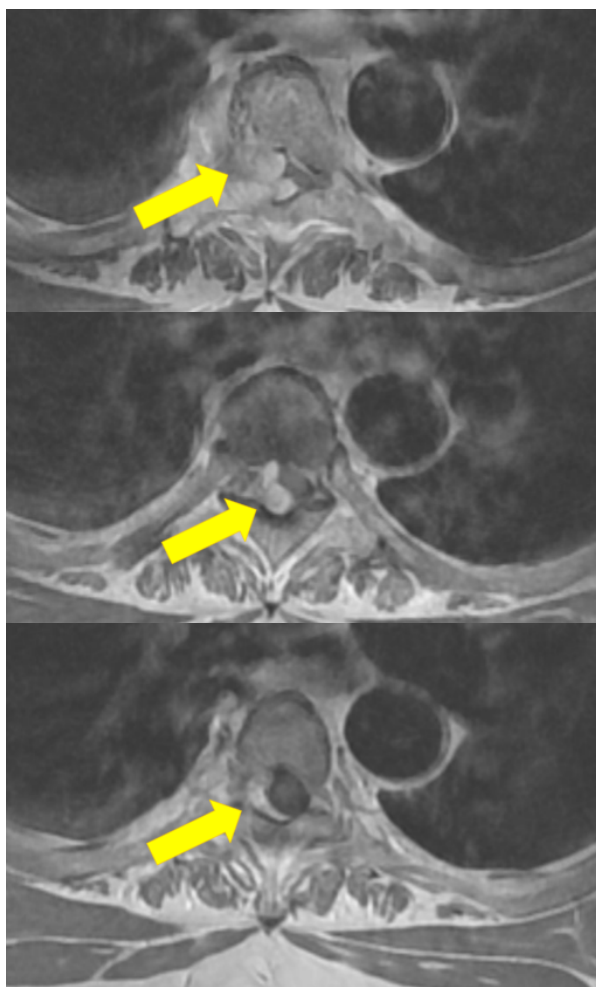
MRI Thoracic spine axial view.
